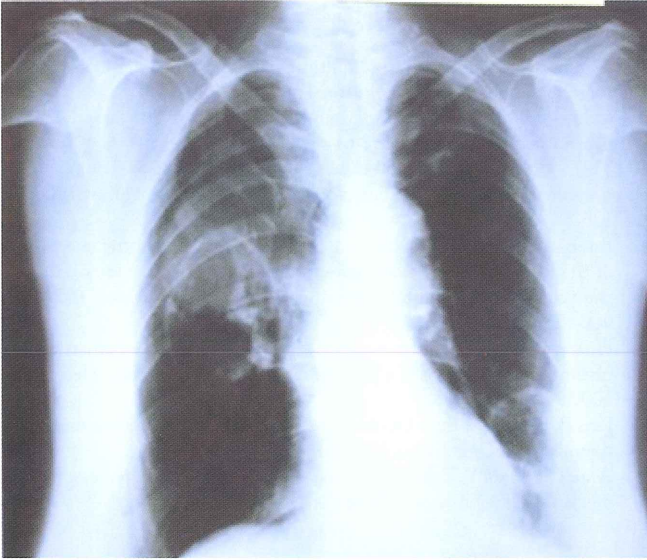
Chest roentgenogram showing a 5x6 cm cavitary lesion in the right upper lobe, a 3x4 cm cavitary lesion superposed with the left border of the heart and an ill-defined infiltrative lesion superposed with the left clavicle.
